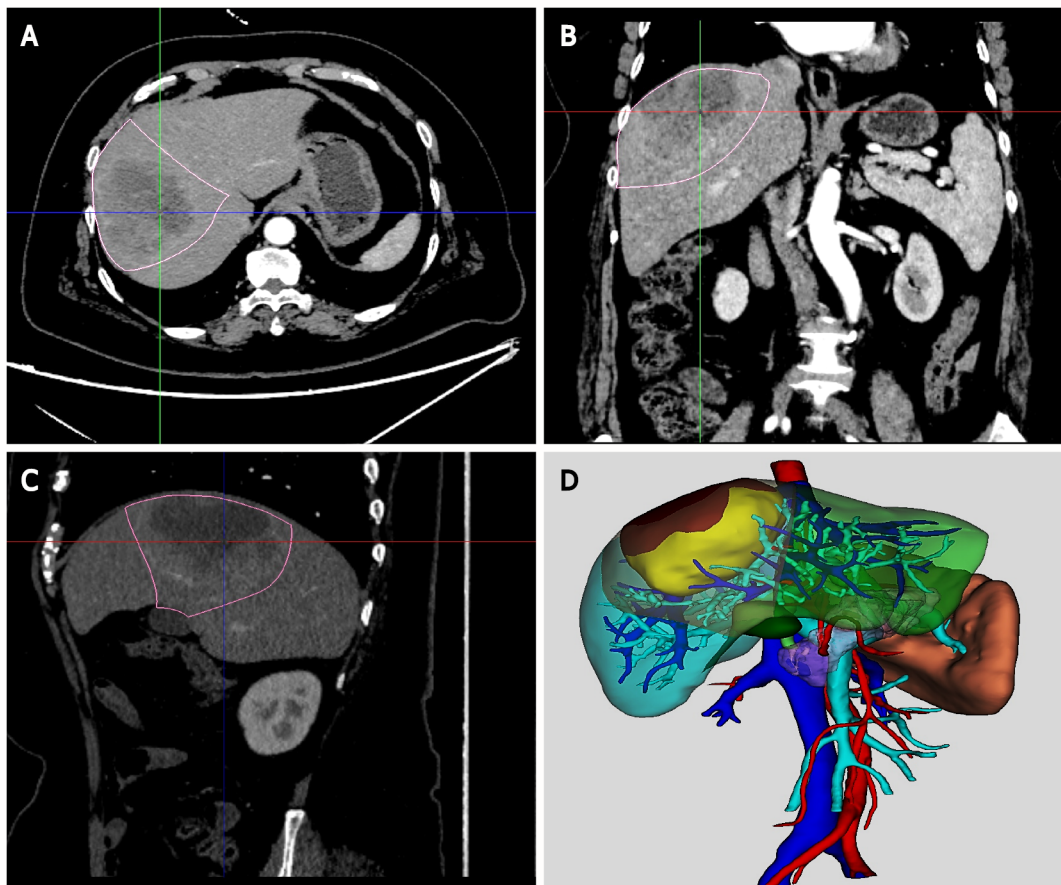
Two-dimensional imaging and three-dimensional reconstruction. A-C: Two-dimensional imaging (2D) abdominal enhanced computed tomography images of a patient with hepatocellular carcinoma; D: Three-dimensional (3D) hologram reconstructed by mixed reality software.
